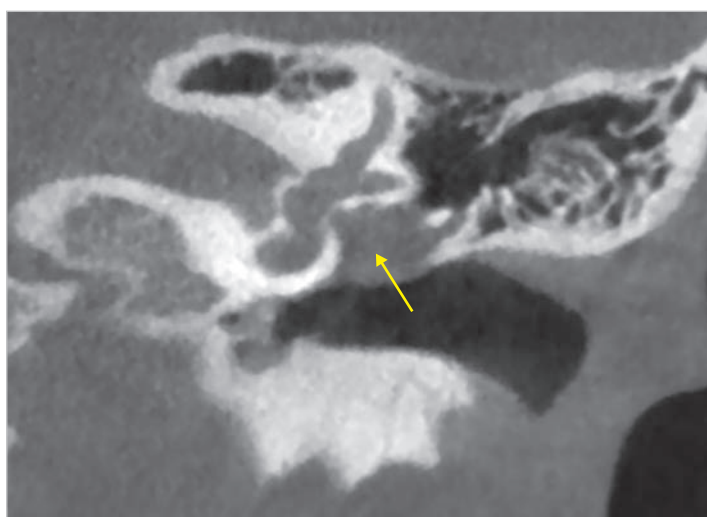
Cone-beam CT scan of the same case, coronal view. The cholesteatoma involves the mesotympanic area, eroding the incudostapedial joint (*arrow*).
